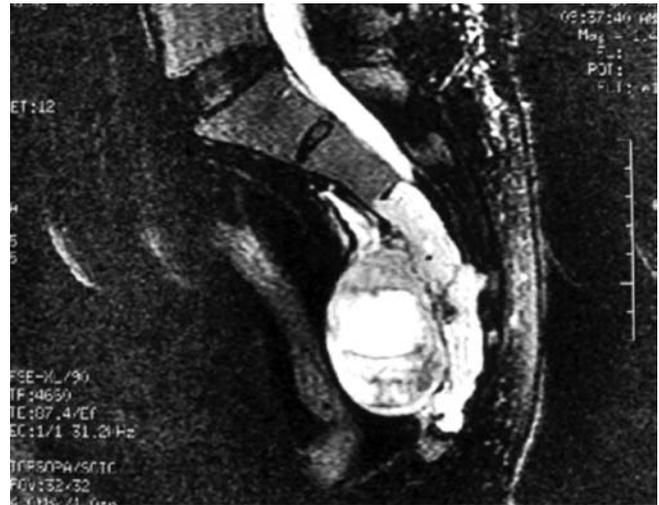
Sagittal MRI T2 of chordoma.
